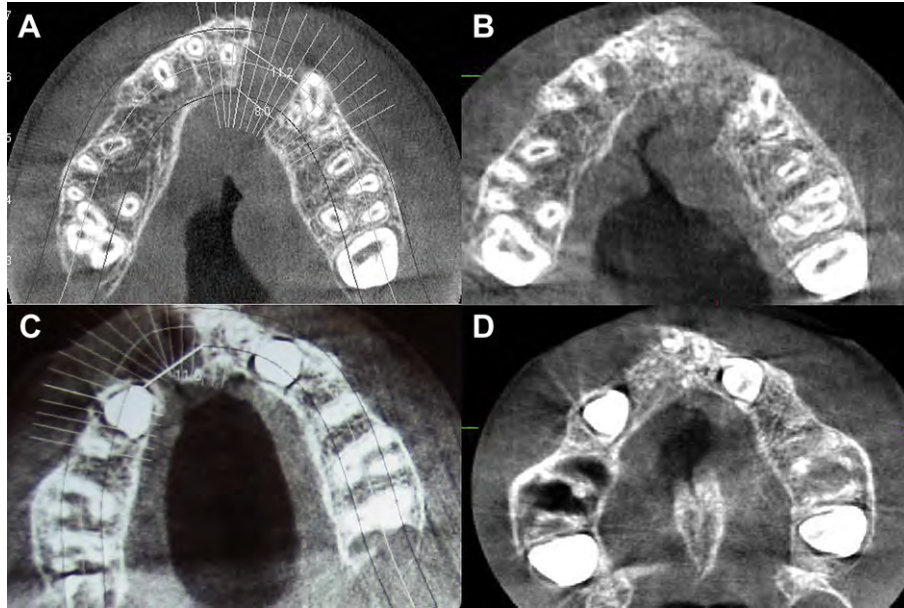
Radiographic investigation 3 months after the surgery demonstrated reconstruction of the nasal floor and filling of the alveolar defect.
